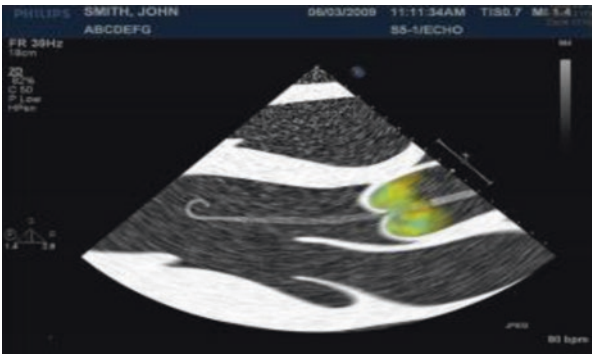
Correct Impella catheter position on transthoracic echocardiogram parasternal long-axis view with color Doppler flow
